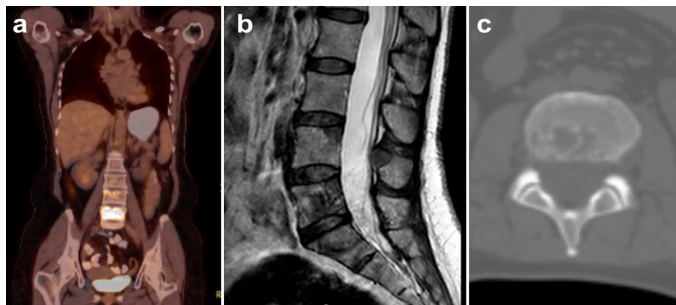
Preoperative PET (a) and sagittal T1-weighted MR imaging showing the level (L5) of spinal metastasis (b), Preoperative axial CT showing the osteolytic metastatic tumor (c)
